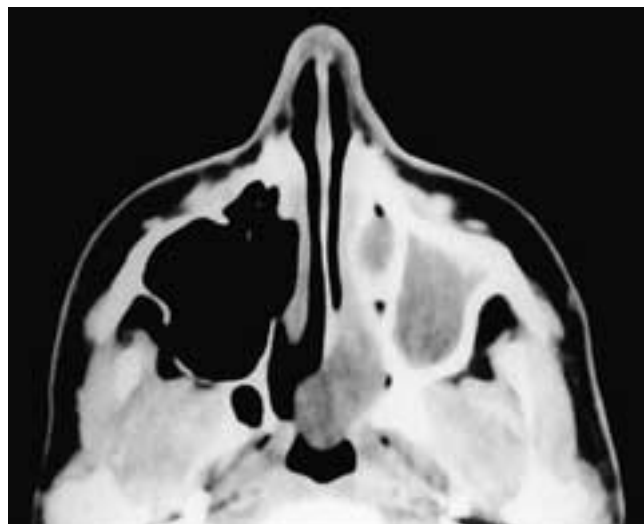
Axial CT scan shows a mucoid density mass filling the left maxillary sinus. It extended through the infundibulum into the left nasal fossa and nasopharynx. This patient had an antrochoanal polyp.
